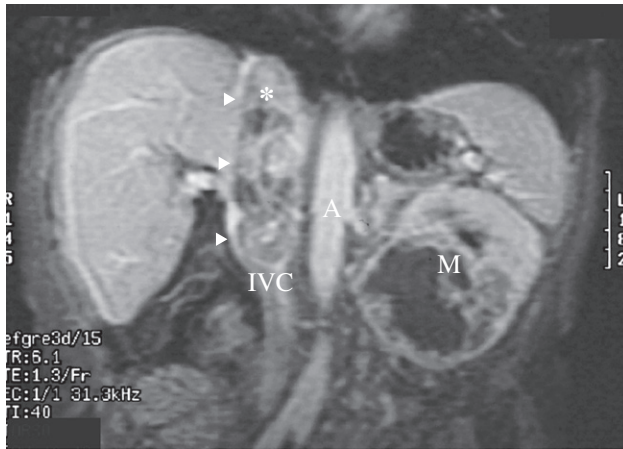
Coronal MRI scan showing a huge left renal carcinoma (M) with tumour extending into the inferior vena cava (IVC) via the left renal vein (not seen on the view). The caval extension of tumour (arrowheads) extends to the top of the IVC (*). A, aorta.
